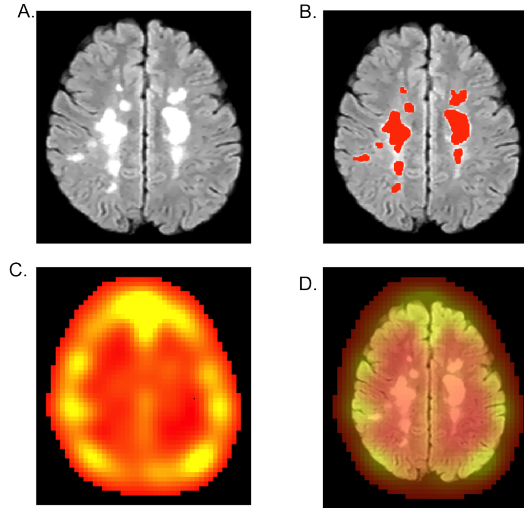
The figure shows the input image with bigger MS lesions (7 - 10cm) (A.), the manually traced mask in red overlaid on the input image (B.), the resulting saliency map (C.), and the saliency map overlaid on the MRI image with MS lesions (D.). The yellow areas are the highly salient areas, whereas the red areas are less salient ones.
